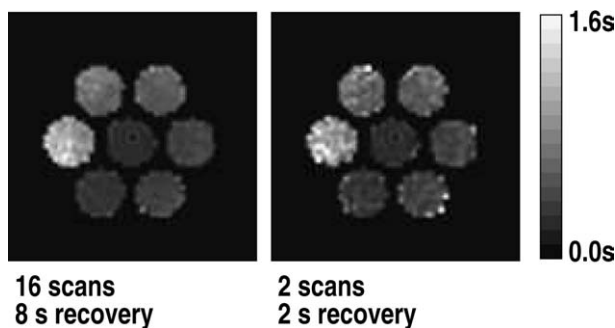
Spin-lattice relaxation ( $T_1$ ) maps by multiple pulse-train MRI. The sample liquid at the center is numbered 7; the others, from the 9-o'clock position and clockwise, are numbered 1–6.
